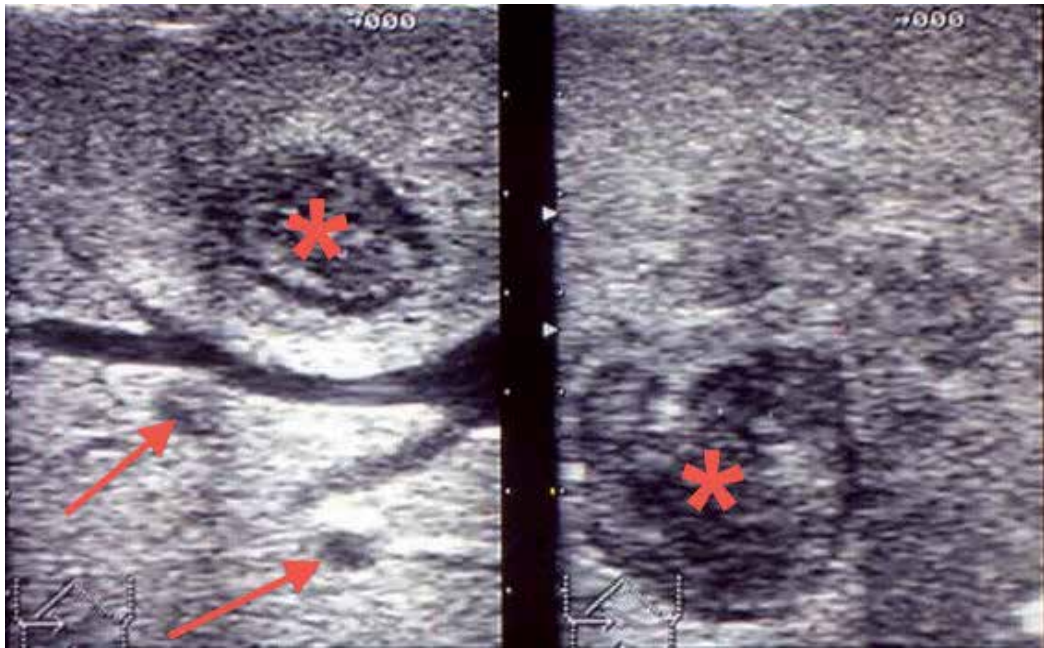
Intraoperative ultrasound examination showing a small HCC of 2 cm (star mark) located in the eighth segment and two minimal HCC (5 and 4 mm) (arrows) in the contiguous seventh segment. The planned resection of the eighth segment was changed to a bisegmentectomy of 7+8.
